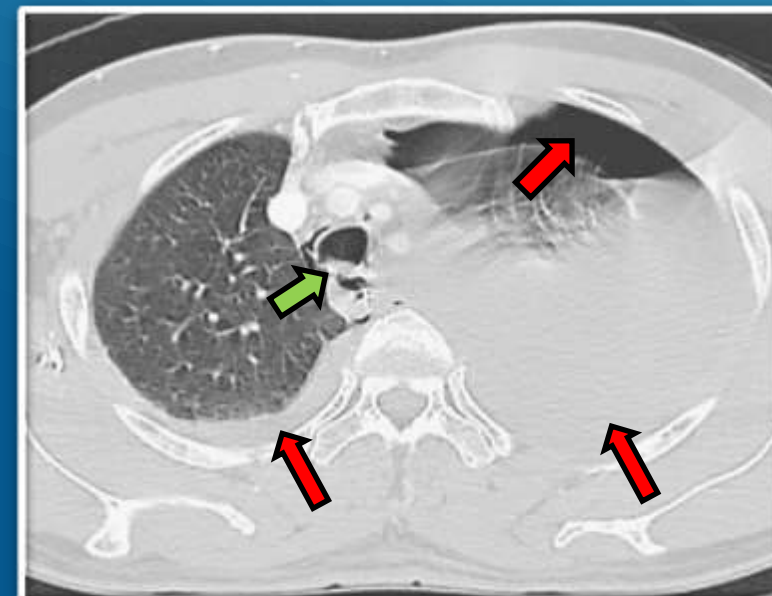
axial CT shows massive paraoesophageal air pocket with suspicious of mucosal tear (green arrow), left hydropneumothorax (red arrow)
